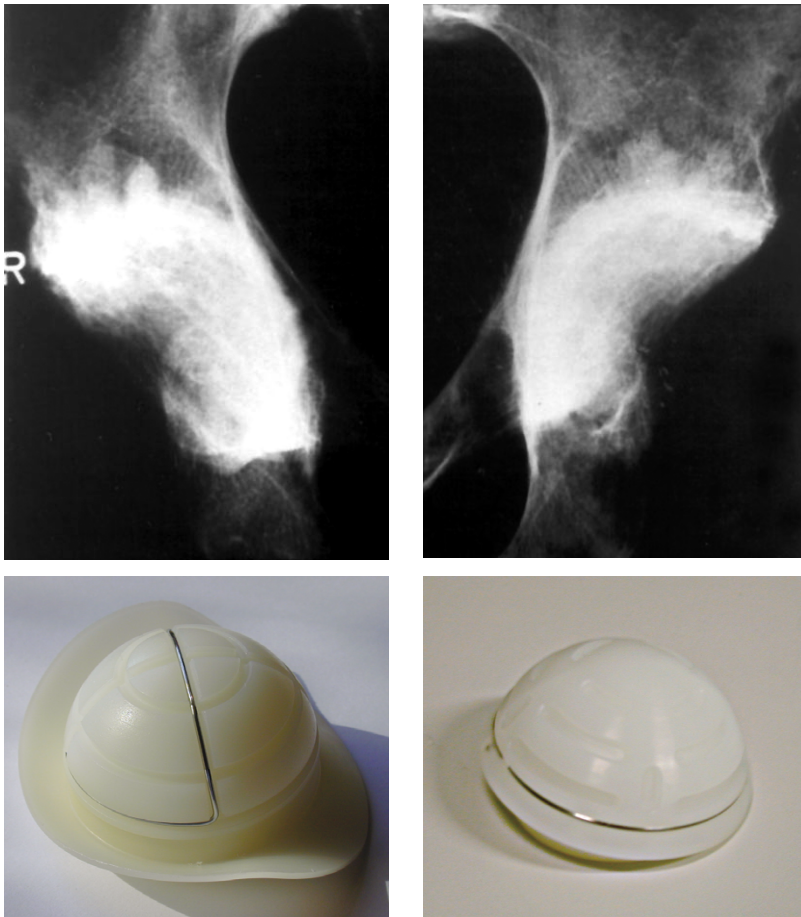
AP radiographs of the paired hemipelvices after cup implantation (right: unflanged cup, left: flanged cup). Note that orientation wires had been removed before insertion.
